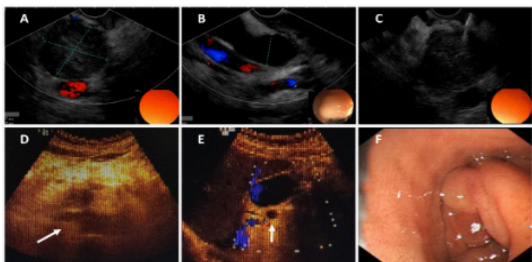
(A). Ultrasonic gastroscopy found a 33x36mm hypoechoic mass of the head of the pancreas at duodenal bulb and descending part, with clear boundaries.
